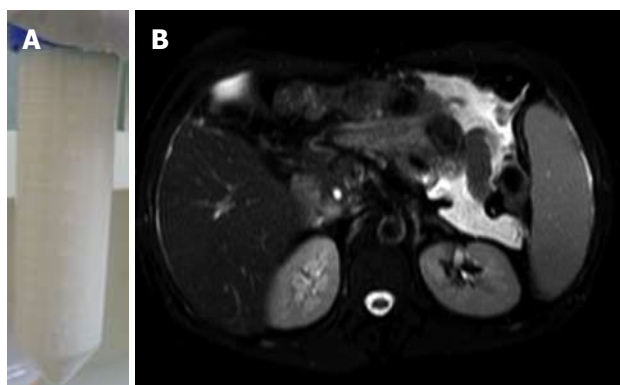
The auxiliary examination for the patient. A: The ascitic fluid had a milky appearance; B: Abdominal magnetic resonance imaging showed hepatosplenomegaly with ascites.
